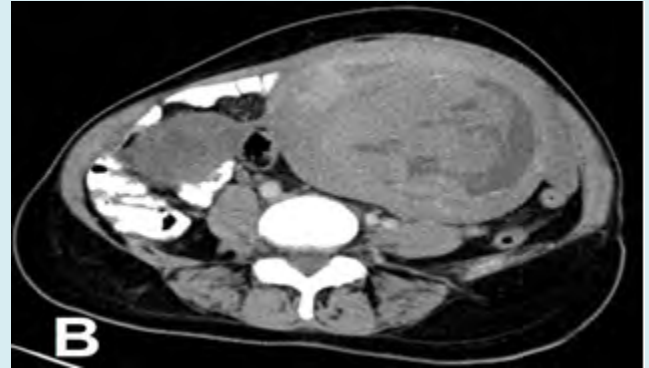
CT abdominal and pelvic with double contrast, axial view.
